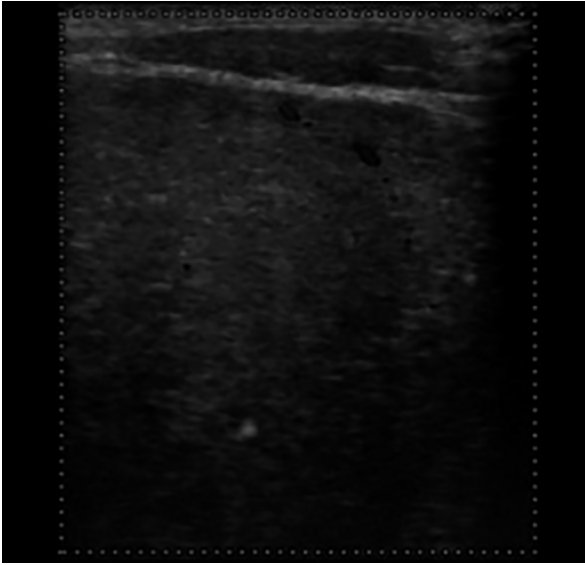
Ultrasonography. Ultrasonography depicts the entire tumor. The tumor appears fusiform-shaped and 10 cm in diameter with clear margin and an isoechoic, vascular region inside.
